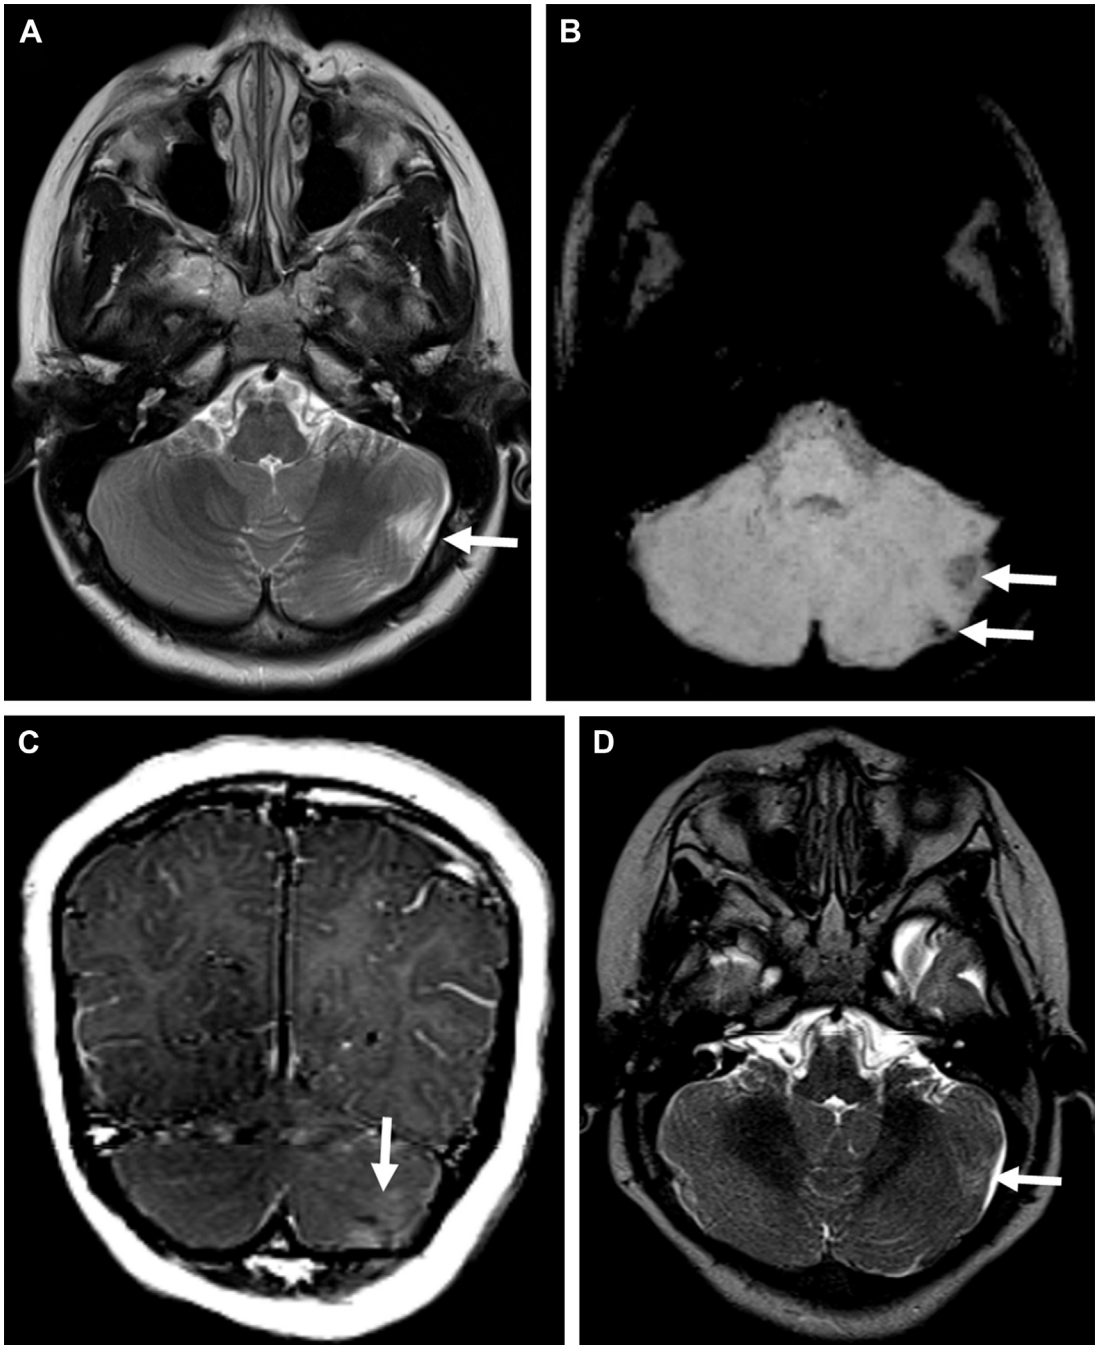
5-year-old girl with TSC. (A) Axial T2-weighted image showing a wedge-shaped hyperintense lesion on the left consistent with a cerebellar tuber (arrow). (B) Axial susceptibility-weighted image (SWI) demonstrates hypointensity within the tuber (arrows), suggesting calcification. (C) Coronal T1 postcontrast image showing striated or zebra-like pattern of enhancement (arrow). (D) Axial T2-weighted image at 10-months of age shows a subtle T2 bright cerebellar tuber on the left (arrow) with interval significant increase in dimension at 5-years of age.
